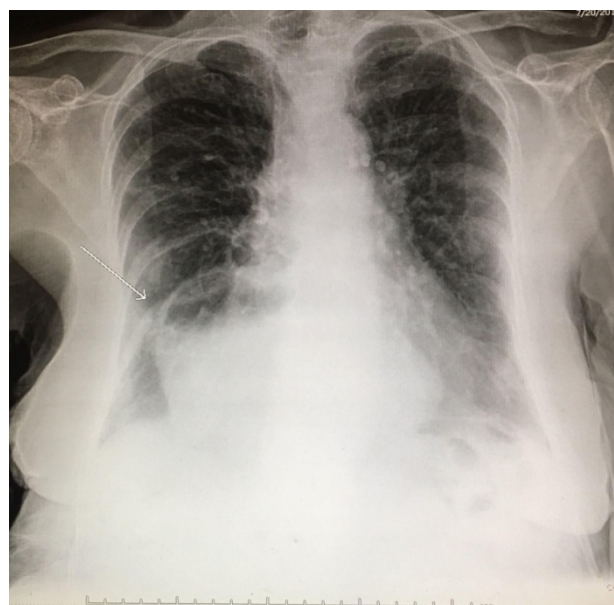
Chest X-rays: Posteroanterior view. White arrow pointing towards hiatal hernia
